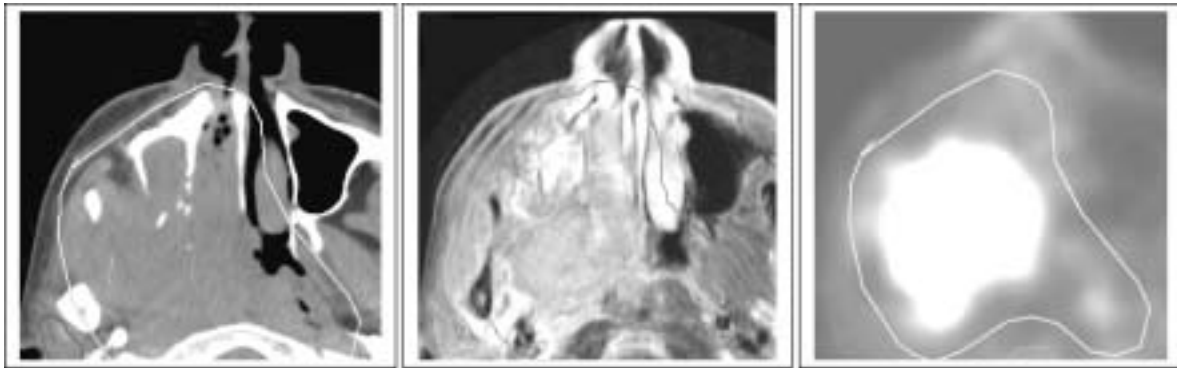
CT, MR, and FDG-PET images for a patient with primary nasopharynx cancer.
